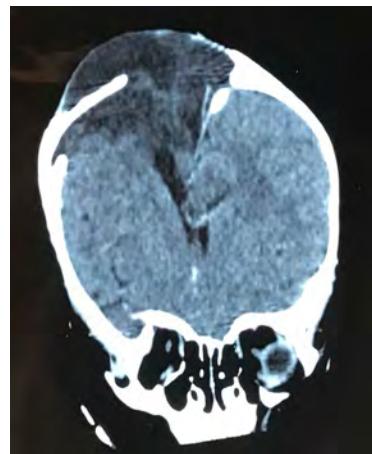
CT scan showing type 3 GSF including parietal bone diastasis with leptomeningeal and porencephalic cyst.
